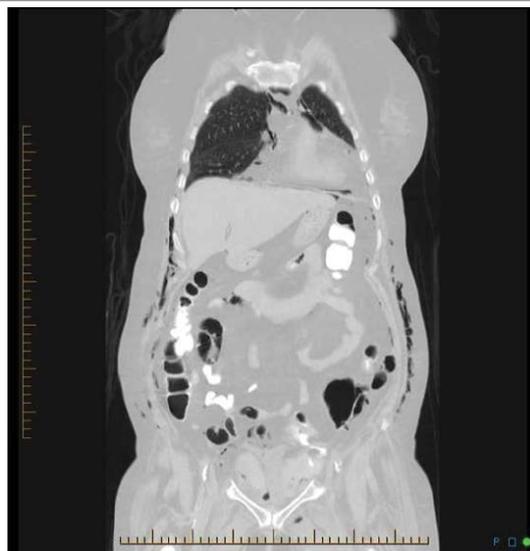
Non-contrast computed tomography scan of chest, abdomen, and pelvis. Axial view demonstrating pneumomediastinum, pneumoperitoneum, and diffuse subcutaneous emphysema.
